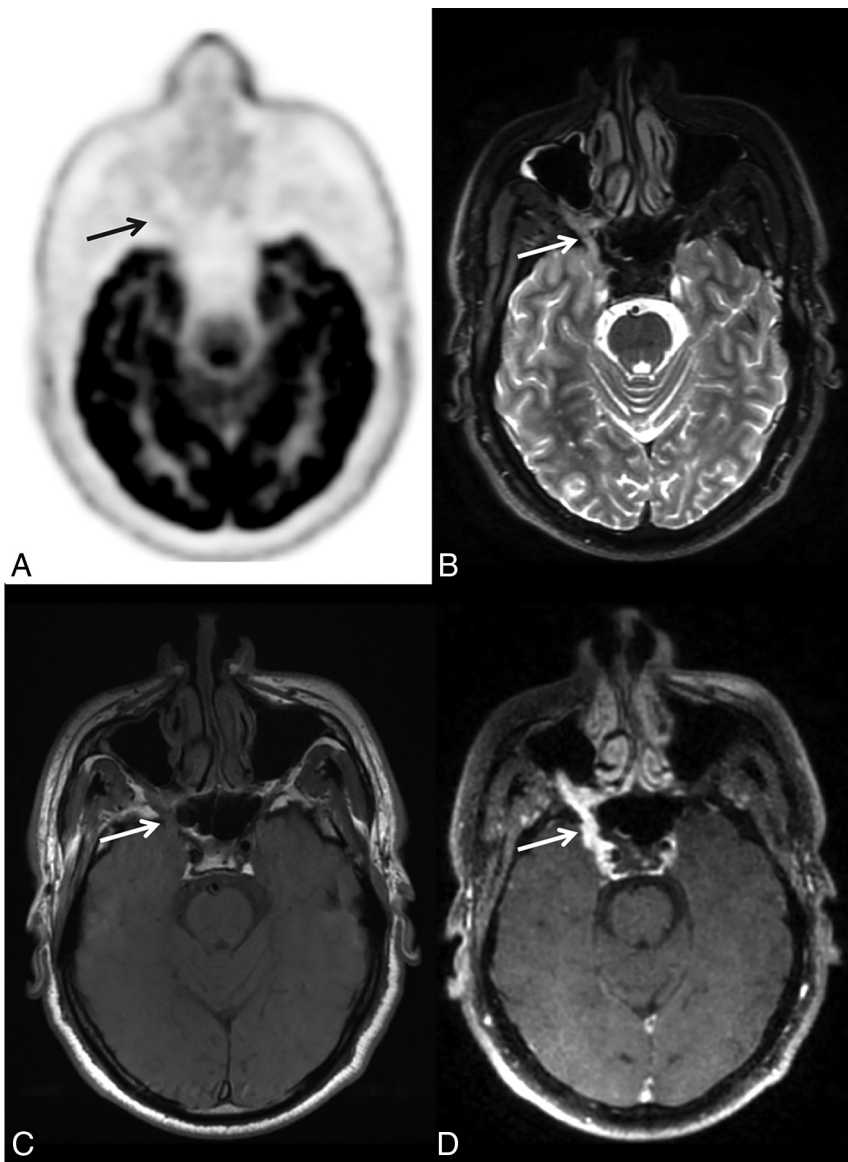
Initial staging of right adenoid cystic carcinoma of a minor salivary gland (palate) in a 55-year-old man. *A*, Axial FDG-PET. *B*, Axial T2-weighted spin-echo (SE) sequence. *C*, Axial T1-weighted SE sequence. *D*, 3D T1-weighted fat-saturated SE postcontrast sequence. On both T1-weighted and T2-weighted MR imaging (*B* and *C*), thickening of the trigeminal nerve is present, with a loss of signal of the fatty tissue in the pterygopalatine fossa, strongly suggestive of perineural spread of the tumor. On the T1-weighted postgadolinium sequence (*D*), high enhancement of the trigeminal nerve is visible (arrow). There is no significant perineural ^{18}F -FDG uptake (*A*); only slight uptake is discernible when guided by MR imaging findings.
